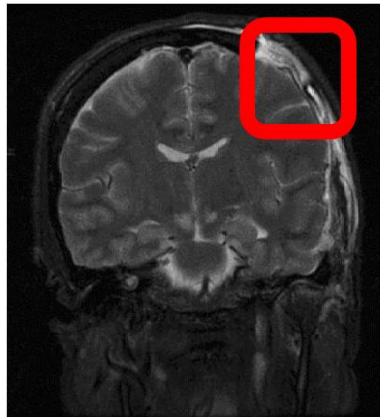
MRI scan of brain herniation
